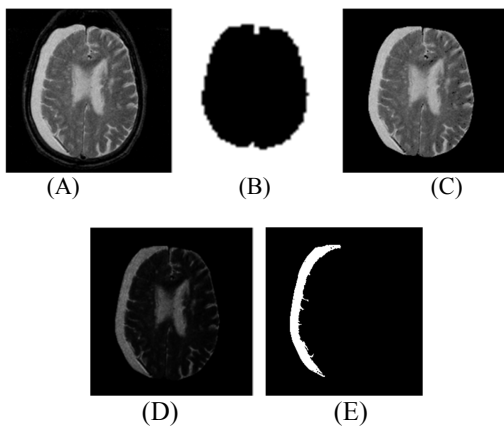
A) Input MRI of Brain , B) complemented wavelet decomposed output, C) applying convex hull, D) after gamma transformation, E) segmented abnormal portion, F) abnormal portion indicated by red marks, G) horizontal contour, H) vertical contour, I) contour of abnormal region, J) localization of abnormal region.
